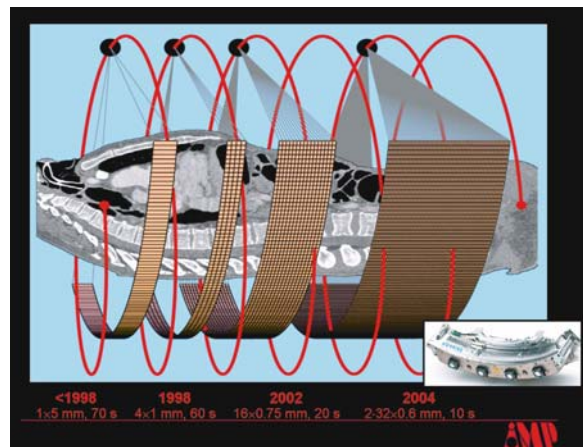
Generations of fan-beam CT scanners: from single-slice to multislice to true cone-beam CT with up to 64 slices
